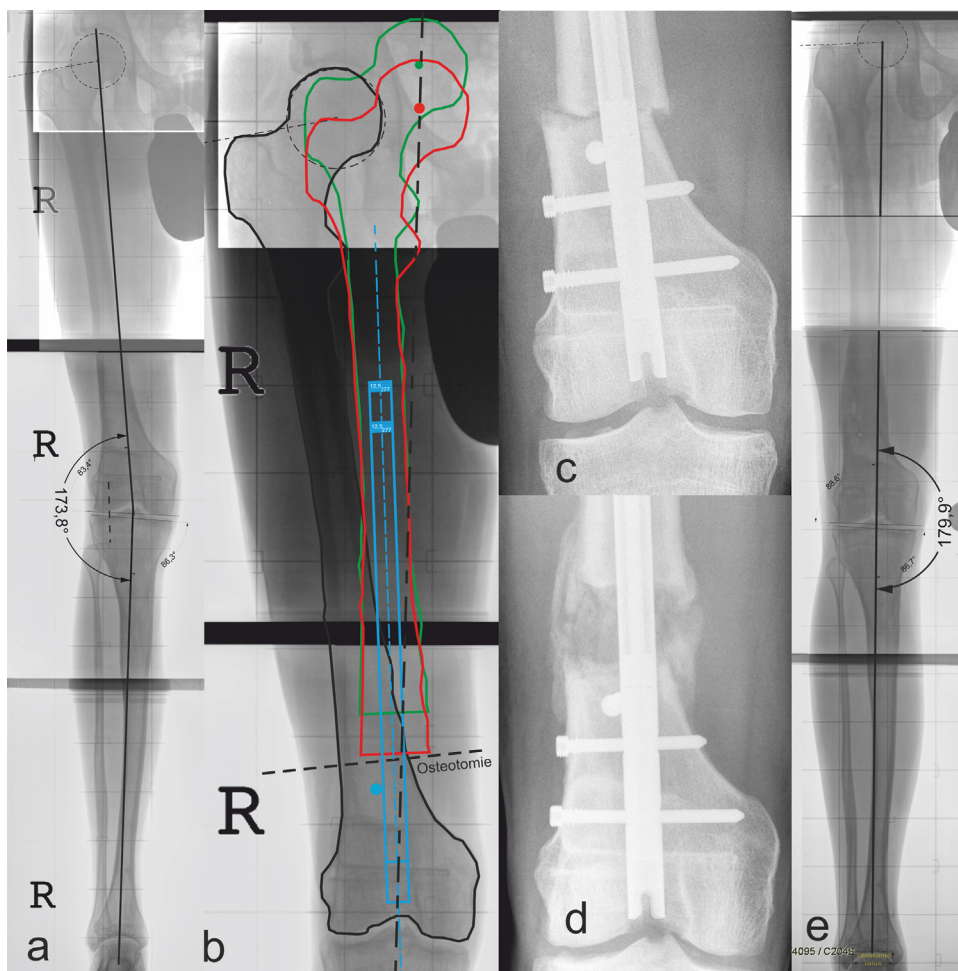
a) Preoperative long standing radiograph with 6.2° valgus deformity and 28 mm shortening b) preoperative planning of the femur using the end point first method (red = postoperative condition, green = post lengthening condition, blue = blocking screw and lengthening nail c) postoperative radiograph with inserted lengthening nail (ISKD) and blocking screw d) post lengthening radiograph e) long standing radiograph at the end of treatment with normal alignment and joint angles.
